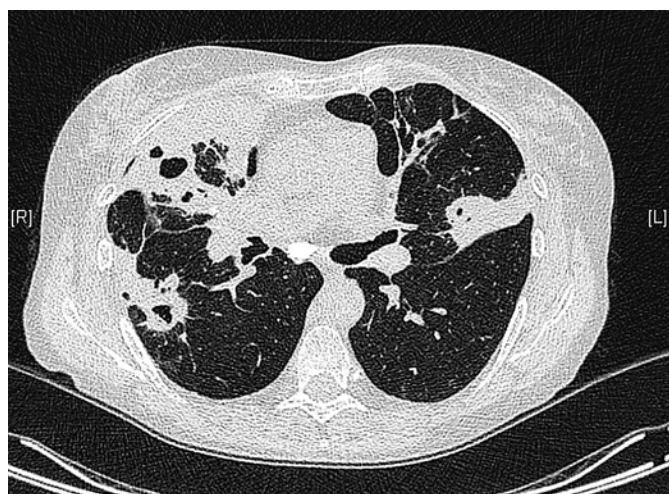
Chest CT in a patient with granulomatosis with polyangiitis showing areas of consolidation, with cavitation within the consolidation and 1 thick-walled cavitated nodule.
